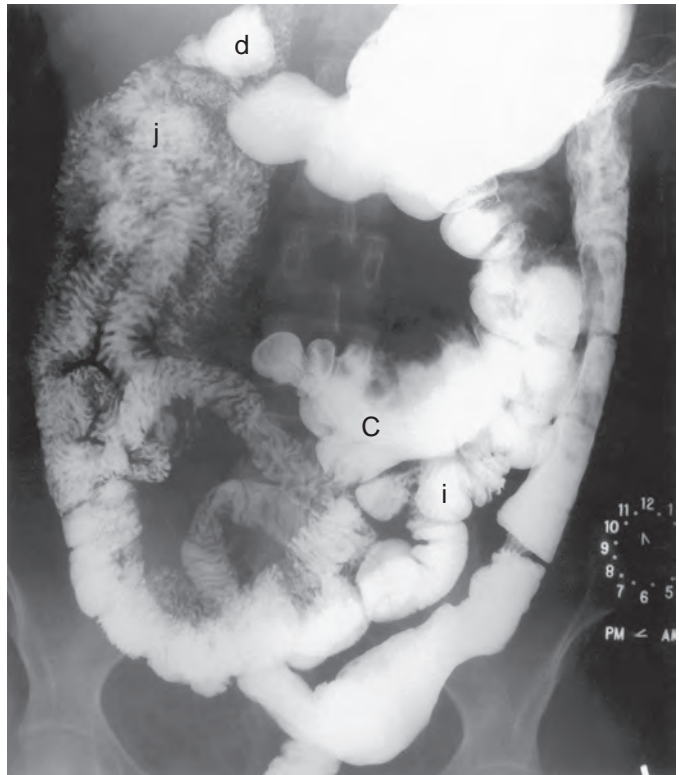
Intestinal nonrotation. This overhead radiograph from small bowel follow-through shows the duodenal bulb (d) in a normal location, with lack of the third and fourth portions of the duodenum and lack of a duodenojejunal junction to the left of the spine. The jejunum (j) is in the right upper quadrant, and most of the ileum is also in the right abdomen, with the distal ileum (i) crossing to the left to join a midline cecum (C). The colon lies in the left abdomen.
